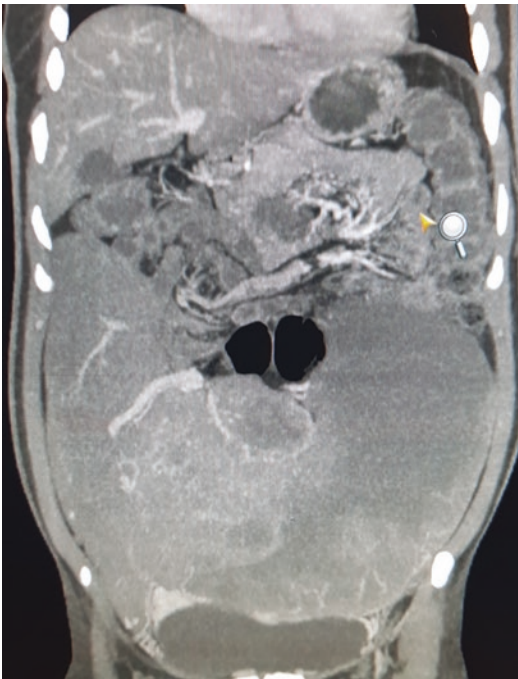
CT scan showing a huge epithelial leiomyosarcoma arising from the omentum. The tumour shows increased vascularity with areas of necrosis
